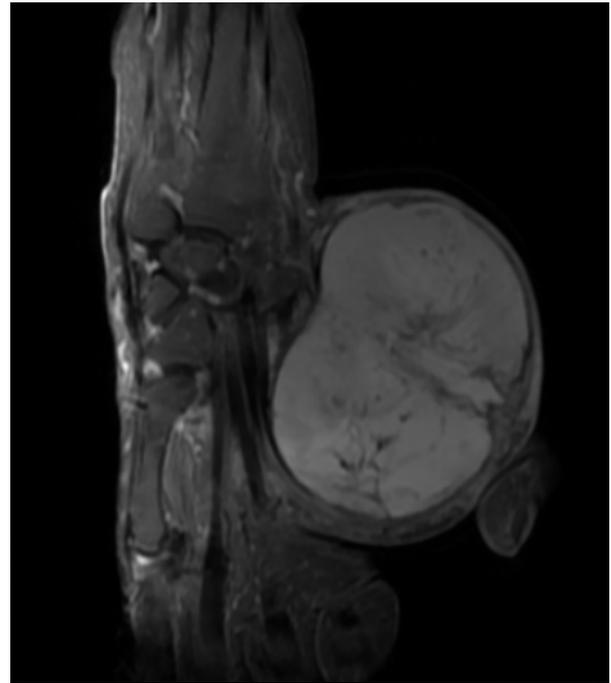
T2-sequence MRI image of the lesion.
